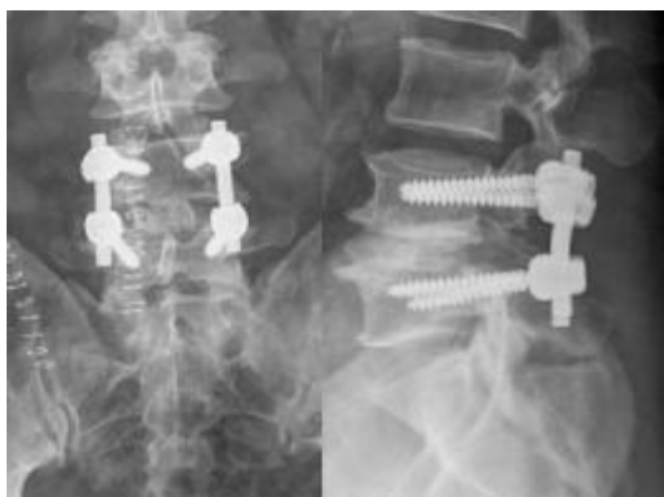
Preoperative MRI and post-operative image of patients with spondylolisthesis of L4-L5.
